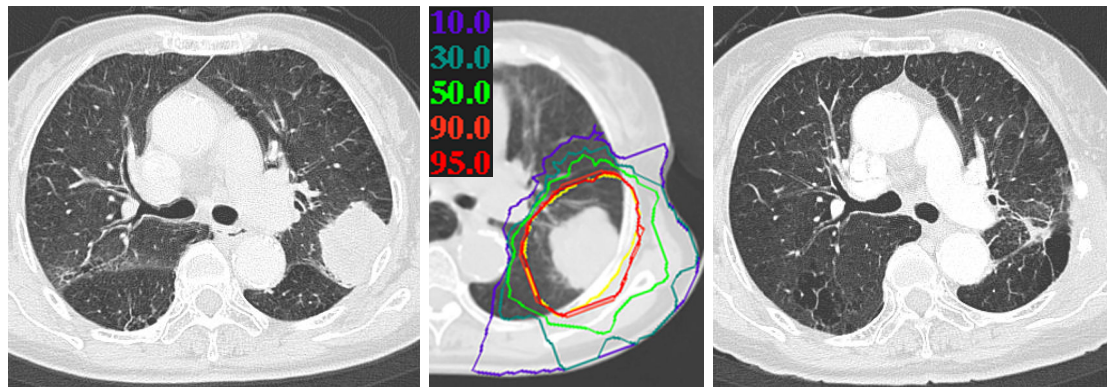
The clinical course of 71-year-old female (T2N0M0 squamous cell carcinoma) after CIRT (40GyE/ single fractionation). An initial CT scan (A), dose distribution map (B), and a CT scan (C) taken 18 months after CIRT are shown. Apparent tumor shrinkage was observed
